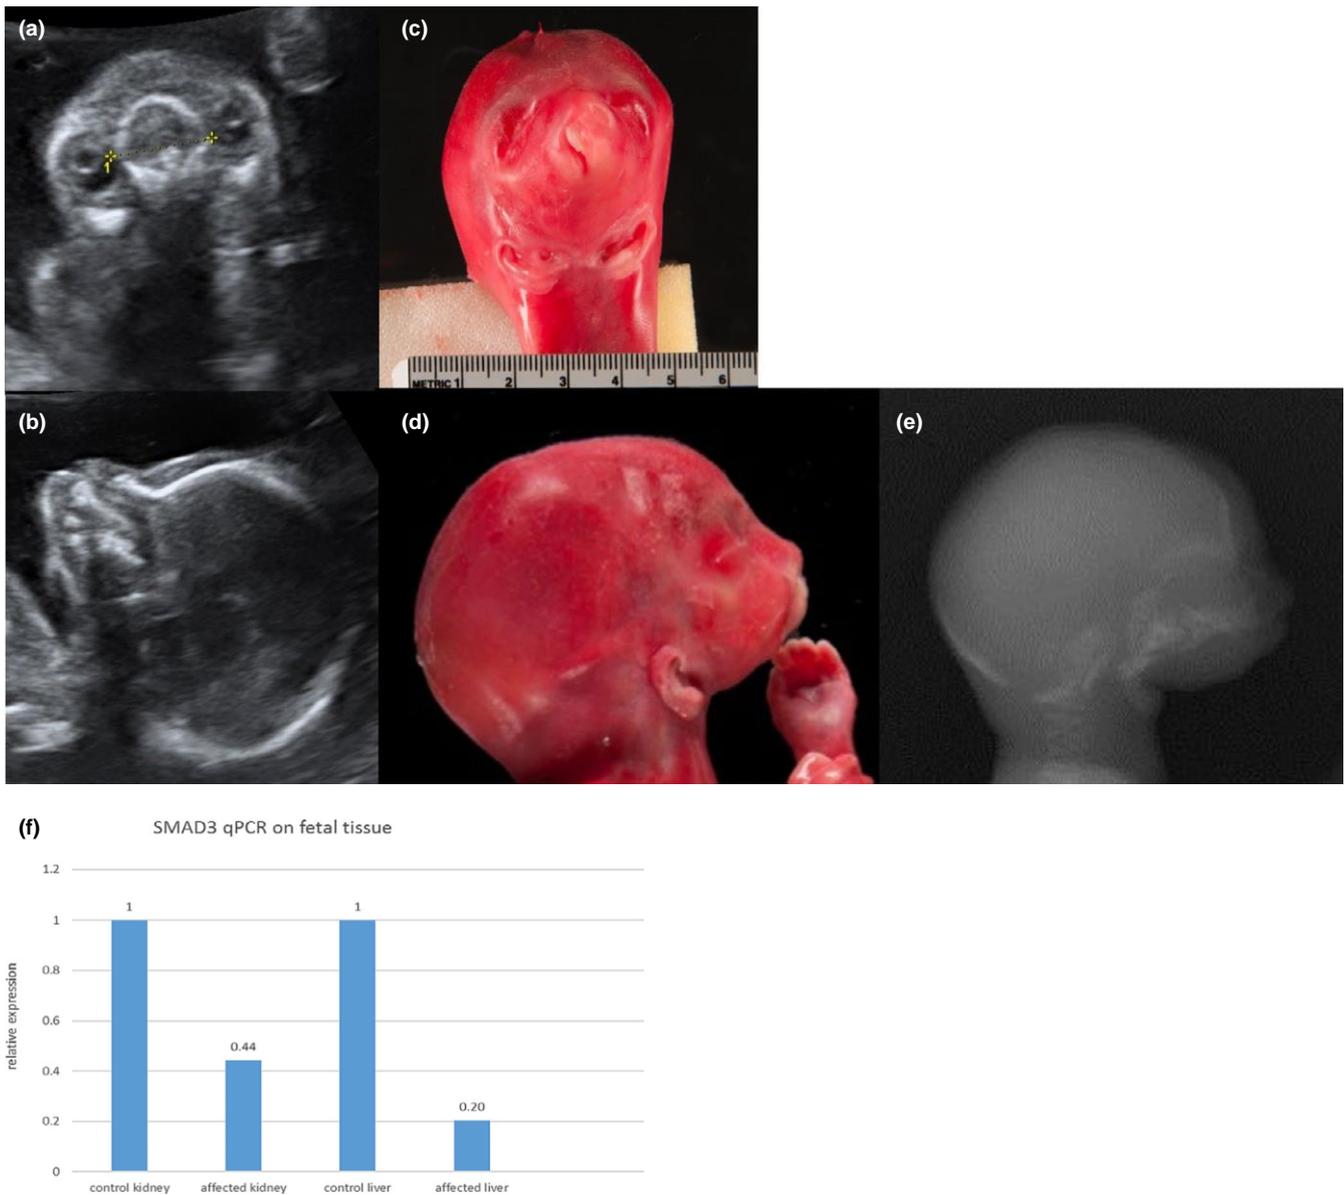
(a–e) The affected fetus at 19 + 2 weeks of gestation in prenatal ultrasound (a and b) and post mortem (c–e) showing cheilognathopalatoschisis, microstomia, absent mandible and ventral median positioned auricles. (f) Relative *SMAD3* mRNA expression in kidney and liver tissue of an age-matched control fetus and the affected fetus (f). RNA was extracted from FFPE tissue, the expression of *SMAD3* was normalized to *GUSB* expression. FFPE, formalin fixed paraffin embedded
